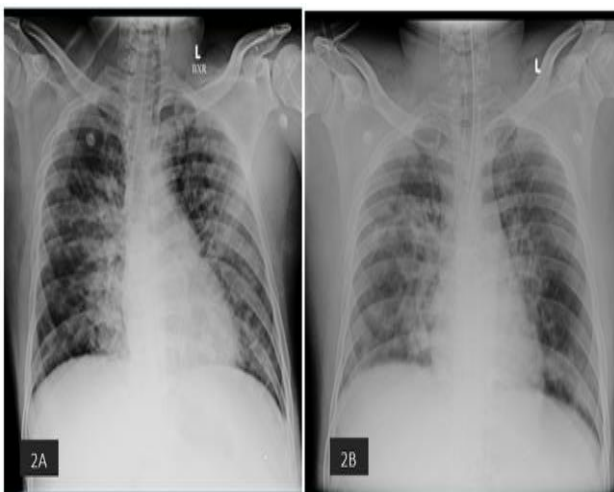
(A and B): Day-1 chest radiographs shows increased bronchovascular markings and day 2 chest radiographs shows bilateral ground glass opacities.
